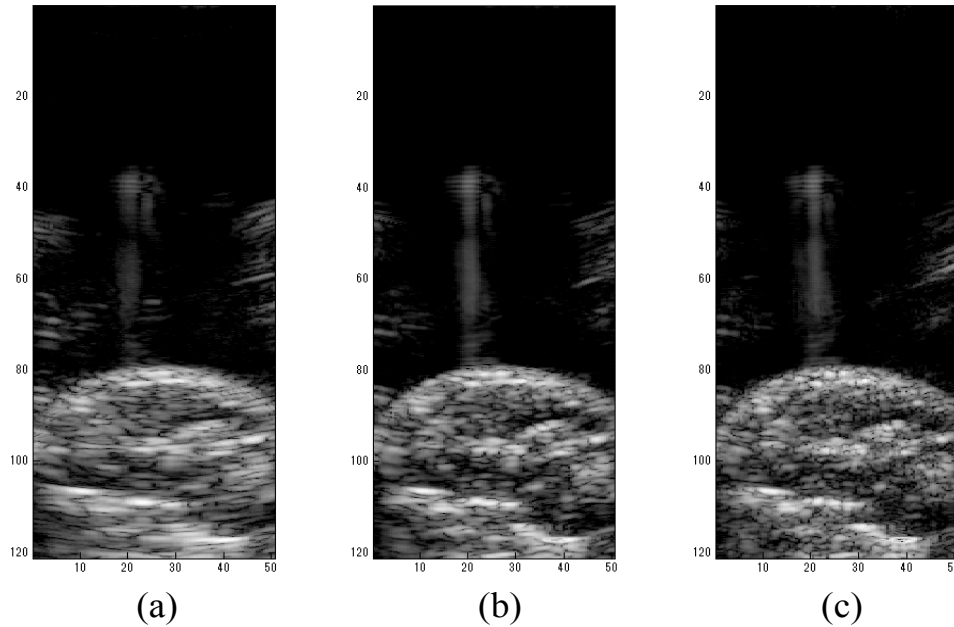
The reconstructed image of the human wrist. (a) Single pose result represents conventional ultrasound image, (b) the STRAtUS imaging result using 10 poses data corresponding to 19.5 mm motion, and (c) the STRAtUS imaging result using 20 poses
